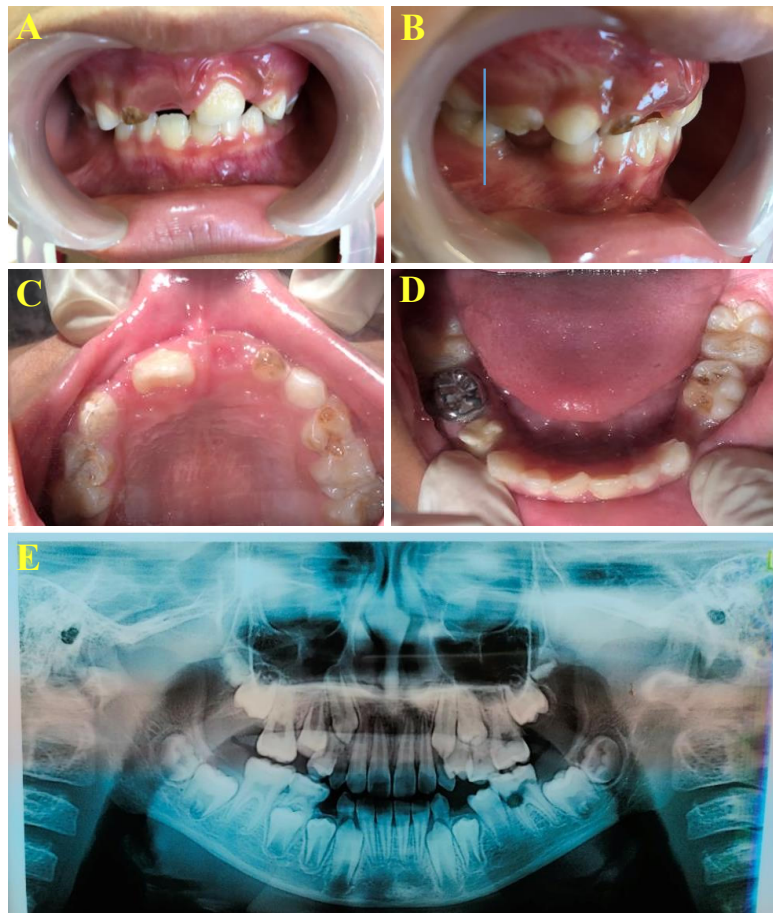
(A) Anterior; (B) molar relation; (C) maxilla-occlusal; (D) mandibular-occlusal; (E) panoramic radiograph.
